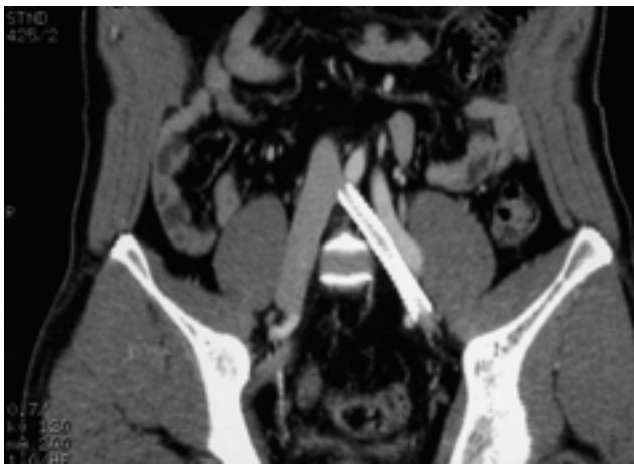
Follow-up CT venography obtained 9 months after the procedure shows patency of the stent without thrombus formation.
